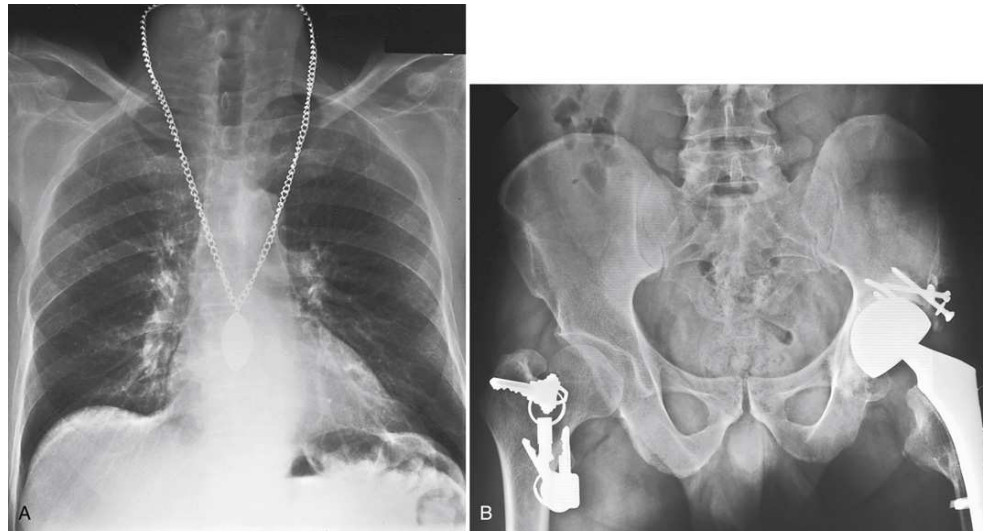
(A) A necklace was left on for this chest radiograph. (B) Keys were left in the pocket of a lightweight hospital robe during the examination of this patient's pelvis. Both radiographs had to be repeated because the metal objects were not removed before the examination.
